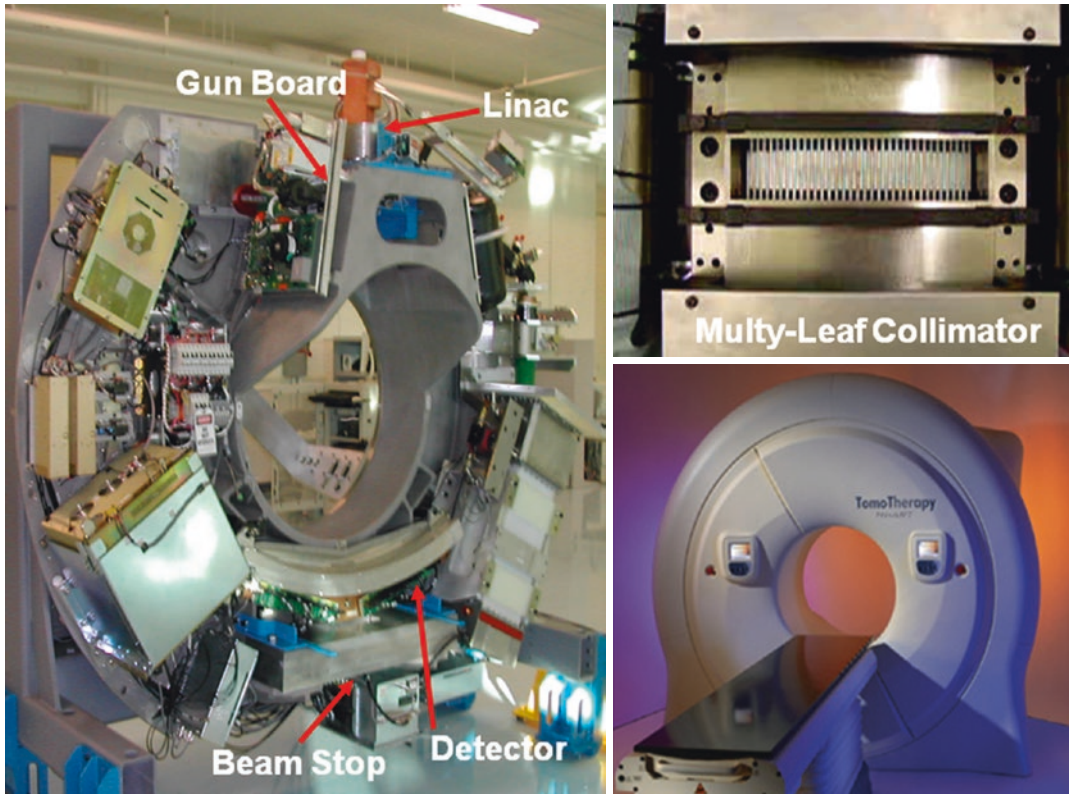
TomoTherapy (TomoTherapy Hi-Art systems; TomoTherapy Inc., Madison, WI) is one of the most sophisticated forms of photon radiotherapy/IMRT machine available. It also includes a megavoltage CT (MVCT) verification (Image Guided system—IGRT) to increase the positional
